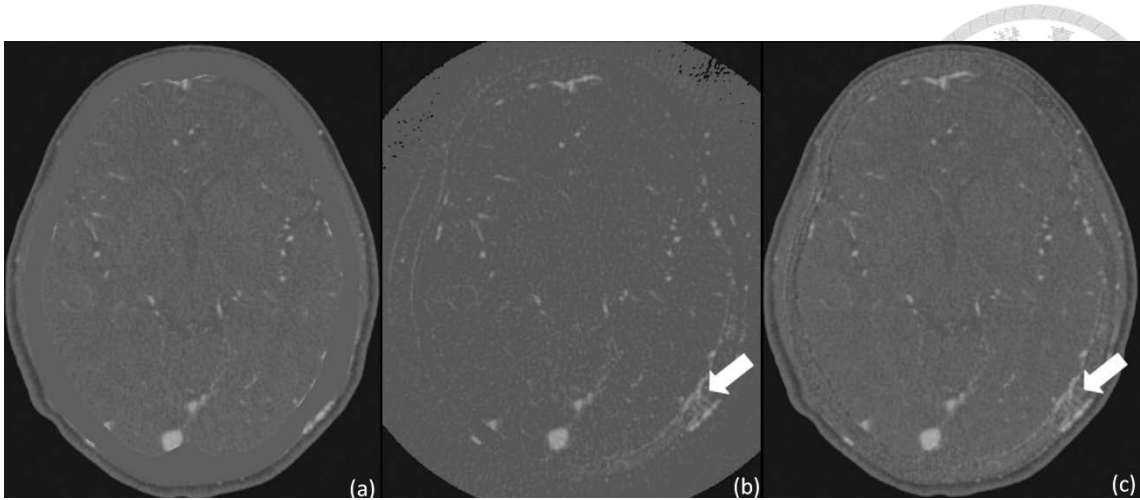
Images in 60-year-old man with pulsatile tinnitus. Images were obtained with (a) MMBE, (b) direct subtraction, and (c) hybrid subtraction (hybrid CTA). (b, c) Arrow = prominent transosseous arteries supplying the arteriovenous fistula. Tiny channels in the bone can be seen; these arteries are not seen on (a). Higher image noise can be seen on (b). In this case, hybrid CTA on (c) outlined the abnormal vessels best.
